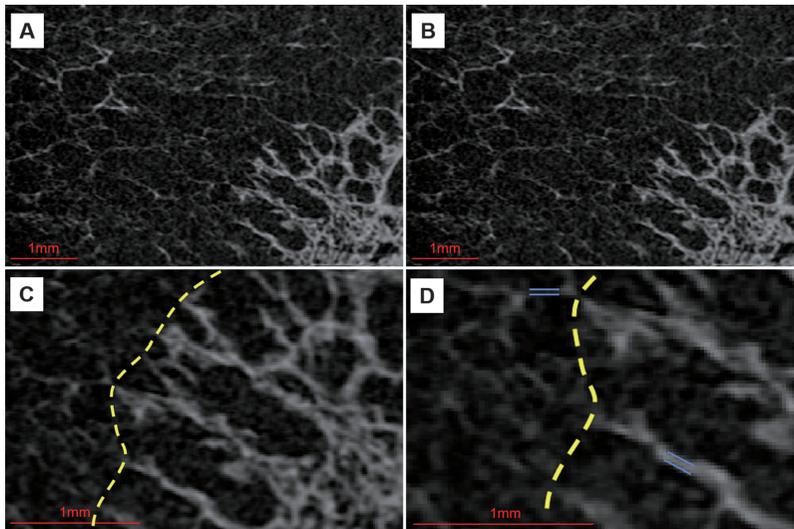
These μ CT images show images of lung adenocarcinoma case
